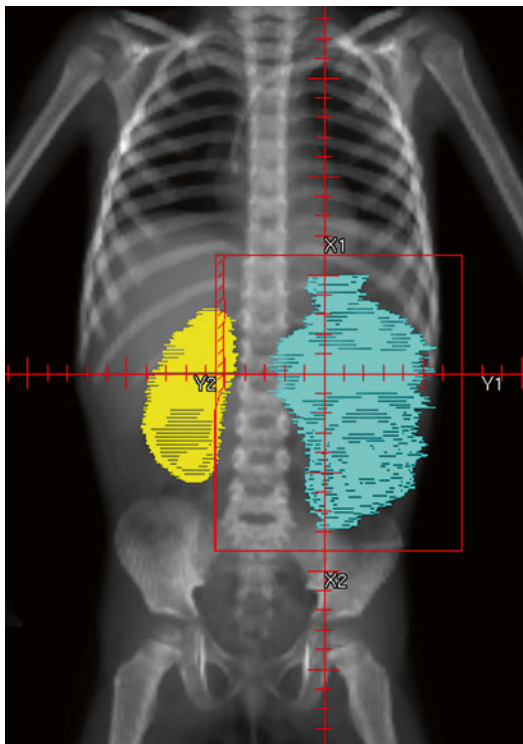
A typical flank irradiation field in a child with left-sided Wilms' tumor. The preoperative CT scan-based tumor volume is shown in *blue* and the right kidney is shown in *yellow*
